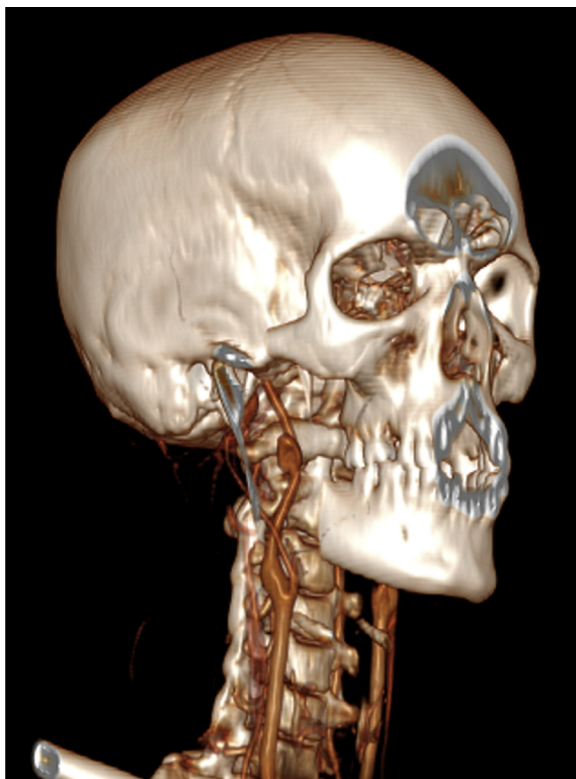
Computed tomography three-dimensional image of right distal carotid artery aneurysm.
